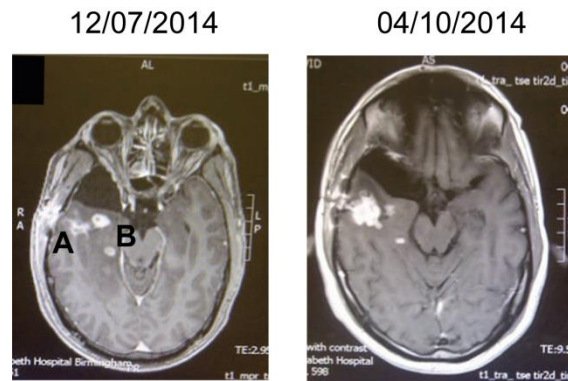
MRI scans from GBM patient showing progression of therapy-resistant foci A but not of therapy-responsive foci B. Images courtesy of Prof. G. Cruickshank.
